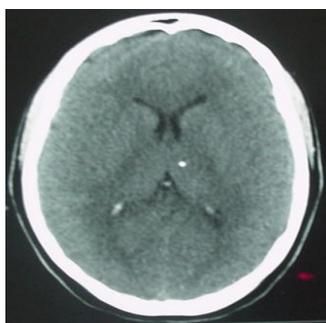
Cranium CT showed a left thalamic calcification.
